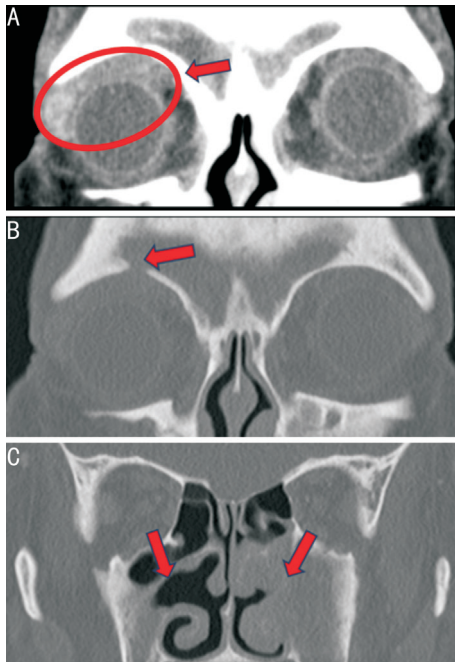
Coronal contrast-enhanced CT (at the initial visit) CT scans show enlargement of the right lacrimal gland and a mass lesion with enhancement at the right upper eyelid (A), with bone defects in the inferior wall of the right frontal sinus (B) and the inner walls of both maxillary sinuses (C). CT: Computed tomography.
